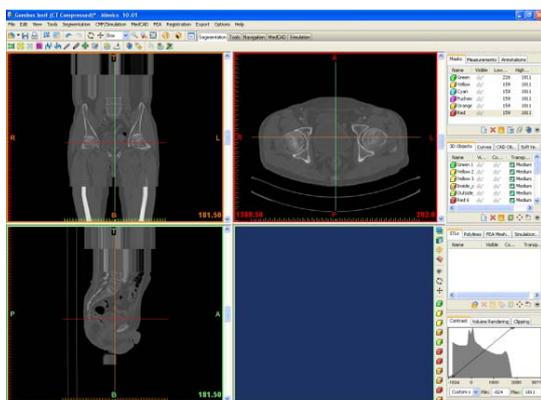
Selection of the CT images
